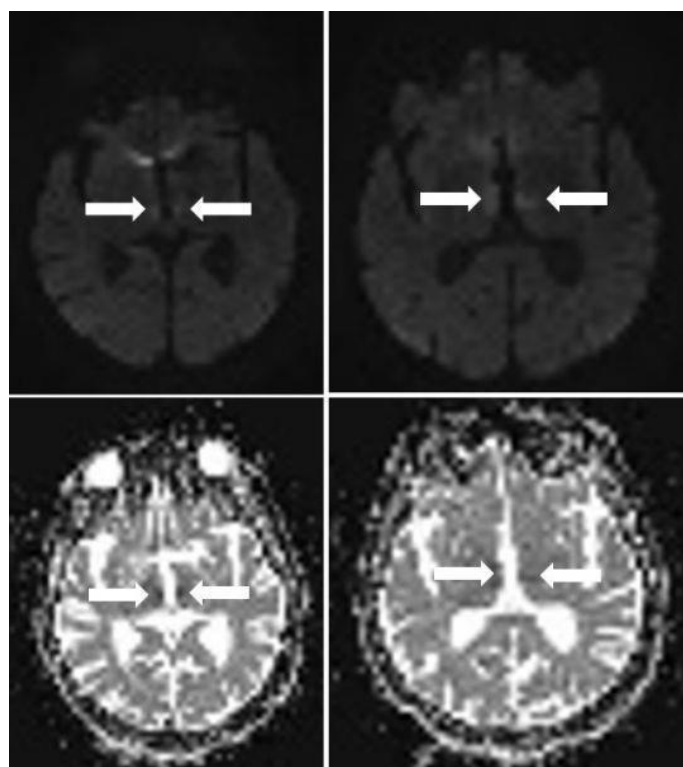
Diffusion-weighted magnetic resonance imaging shows bilateral restriction on medial section of thalami
